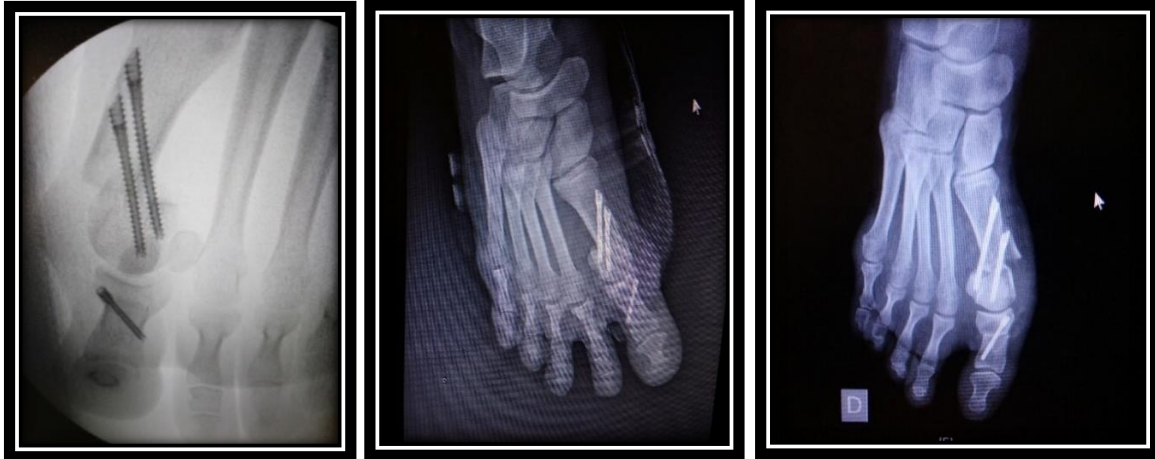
Post operative X-ray (face): First metatarsal chevron percutaneous osteotomy
